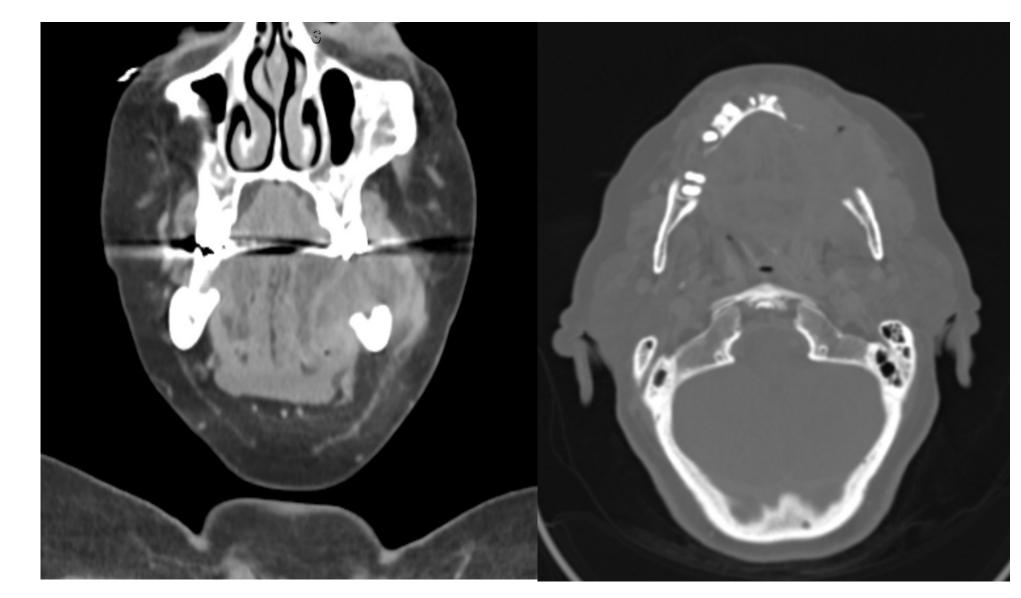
Pre-Operative CT Neck with contrast of patient with SCC of L retromolar trigone eroding into mandible
